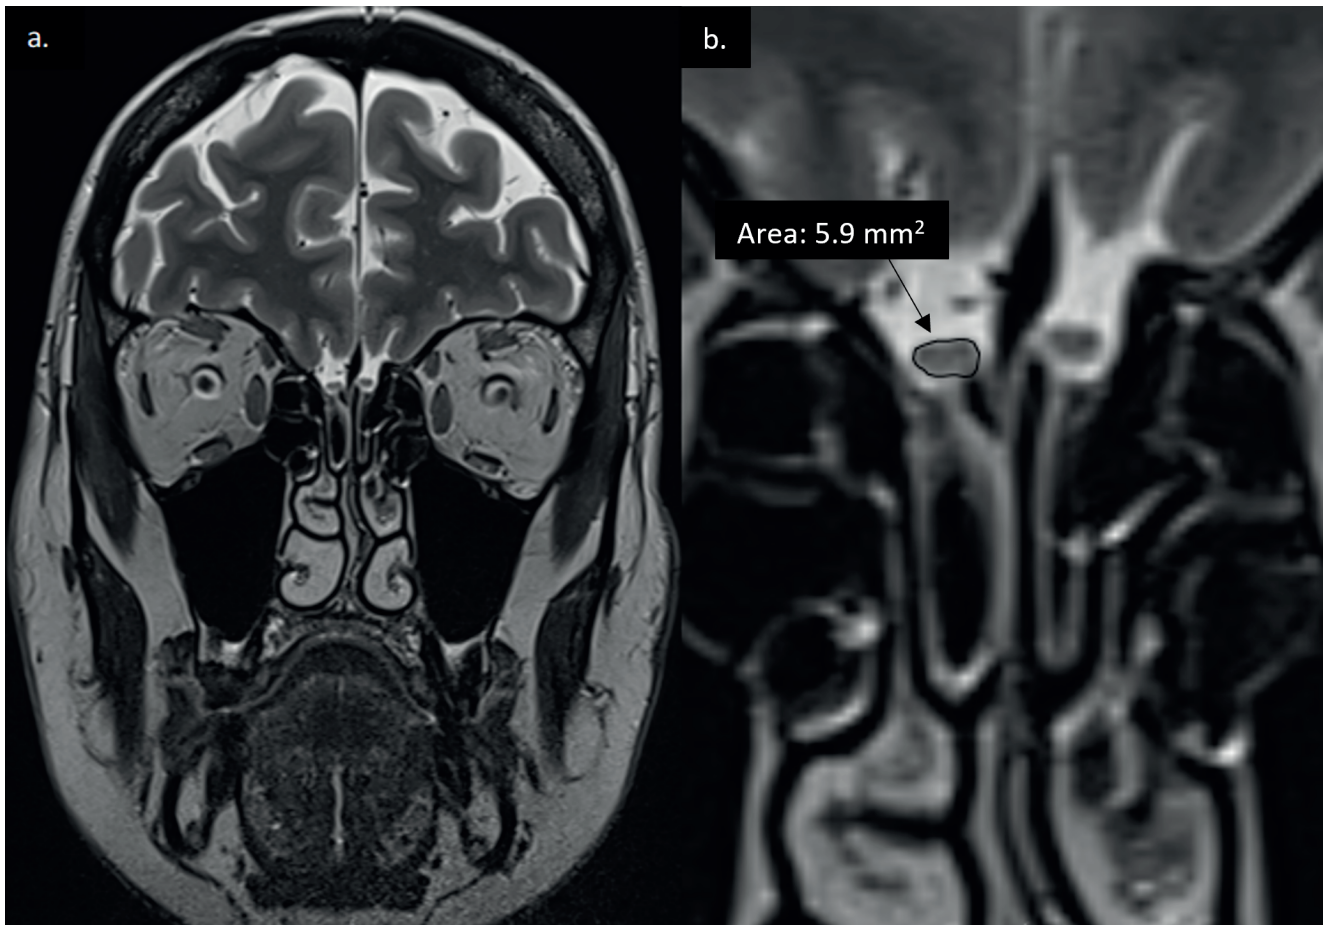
Coronal view of the brain MRI (3 Tesla) as seen on the PACS software: A) Zoomed out. B) Zoomed in on the olfactory bulbs, with the circumference of the right olfactory bulb delineated and the area calculated.
